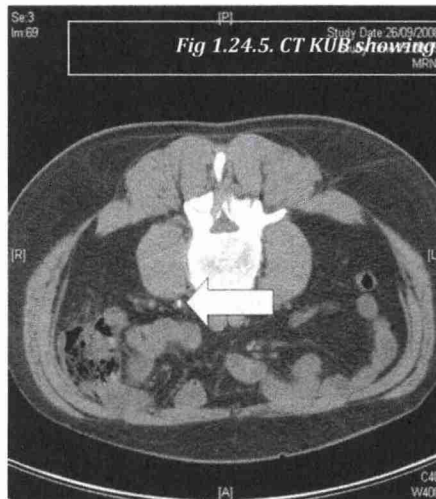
CT KUB showing stones
